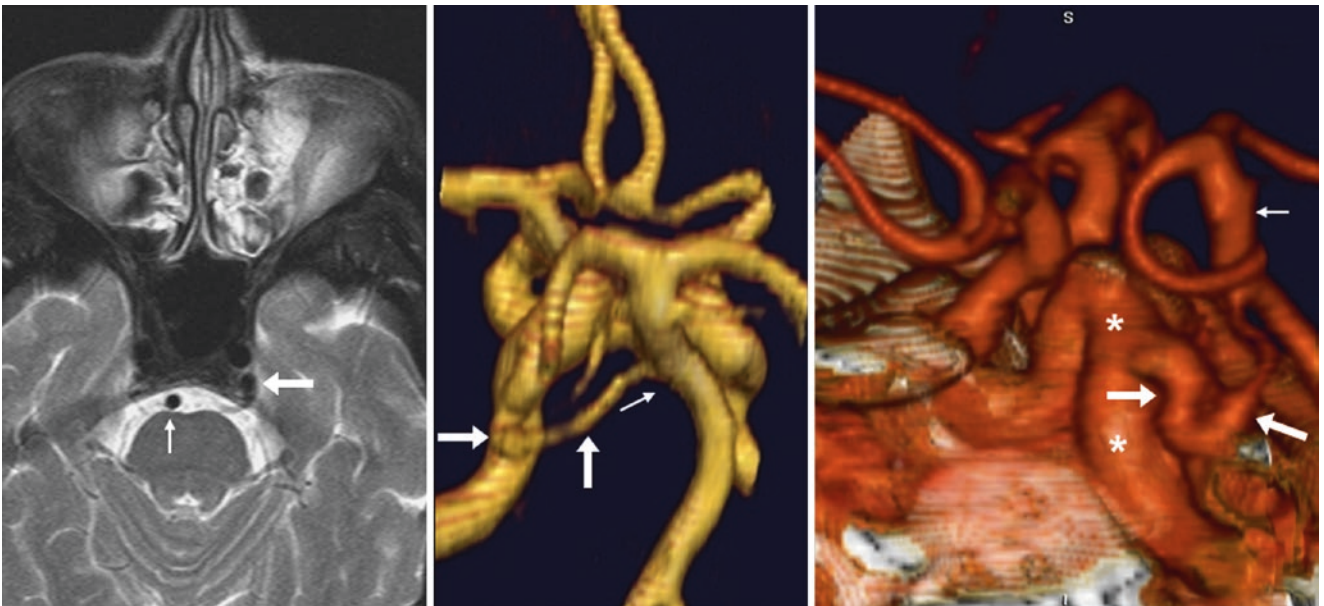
In this 78-year-old, an axial T2WI MRI (*left*) depicts a left PTA (*large arrows*) lateral to the sella, arising from the left ICA and oriented towards the mid-basilar (*thin arrow*). On a 3DTOF MRA PA
